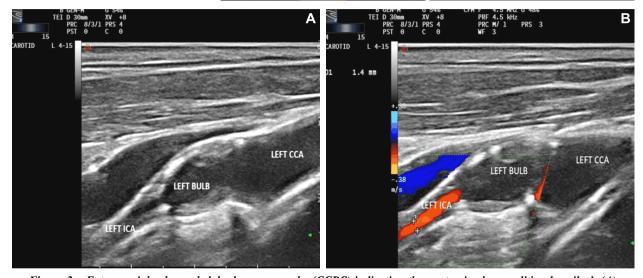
Extracranial color-coded duplex sonography (CCDS) indicating the anatomic abnormalities described: (A) B-mode imaging (left ICA hypoplasia); (B) Color Doppler flow imaging (left ICA hypoplasia). ICA: Internal carotid artery; CCA: Common carotid artery.
